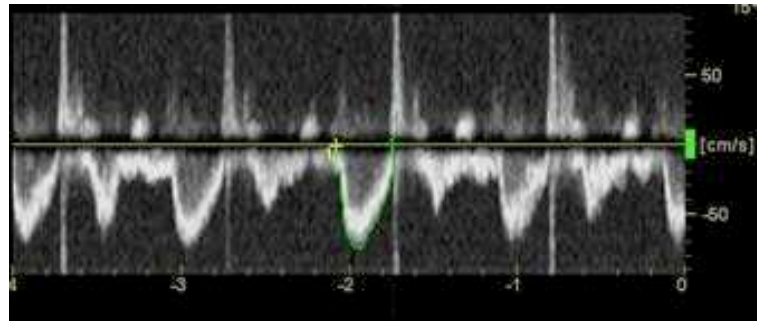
Velocity time integral spectrum trace (highlighted in green) of aortic blood velocity with in-built ultrasound velocity trace measurement software (GE Healthcare, United Kingdom).
